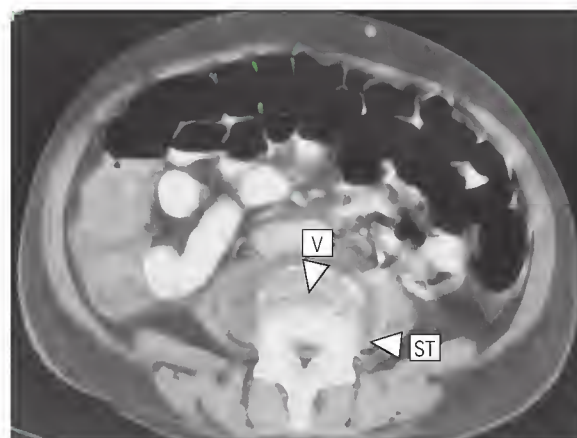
Vertebral osteomyelitis. A computed tomography scan, axial view, demonstrates destruction of a vertebral body (V) with soft tissue extension (ST) into the paravertebral space.
